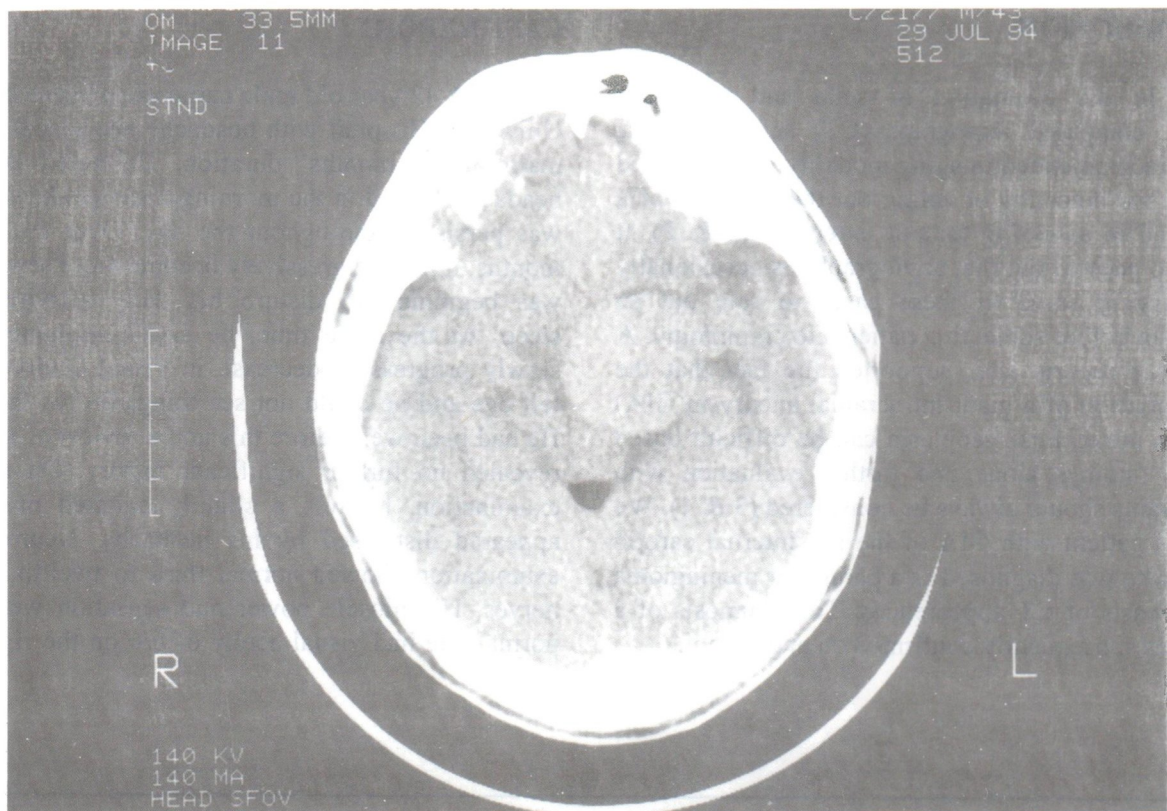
Pre contrast CT scan of the brain showing a well defined hyperdense mass in the left parasellar region.
